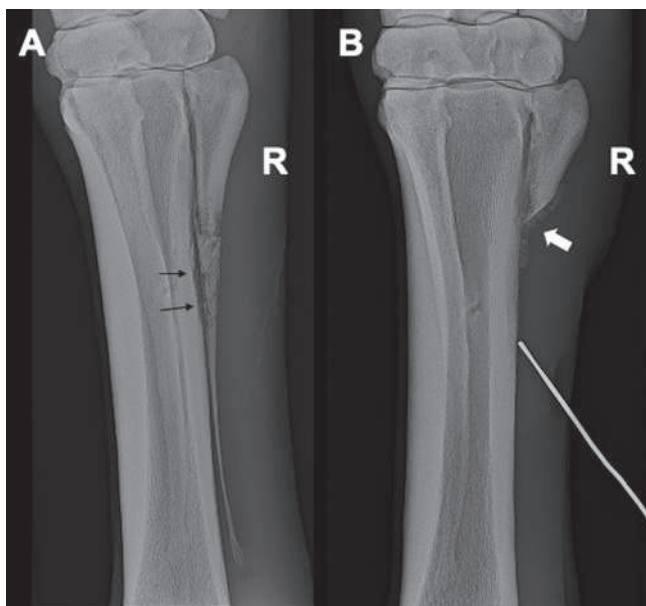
(A) Dorsolateral-palmaromedial oblique radiographic view of the right MCIV in case 5 (10 days after injury). Moderate diffuse soft tissue swelling around MCIV and multiple faint fracture lines in MCIV are evident, and the overall bone opacity of the fractured area of MCIV is markedly reduced. Mild irregular new bone formation with permeative lysis of the cortices of MCIII and MCIV are apparent in the metacarpal interosseus space indicative of osteomyelitis (black arrows). (B) Dorsolateral-palmaromedial oblique radiographic view of the right MCIV in case 5 (6 weeks after surgery): Moderate soft tissue swelling and irregular palisading periosteal reactions along the abaxial contours of MCIII and MCIV are seen. Persistent irregular new bone formation with permeative lysis within the metacarpal interosseus space is indicative of osteomyelitis (white arrow). A metal probe has been inserted into a draining tract and points toward the distal margin of the periosteal reactions on MCIII. | (A) Röntgenologische dorsolaterale-palmaromediale Schrägaufnahme des rechten MCIV des Fall 5 (10 Tage nach der Verletzung): Mittelgradige, diffuse Weichteilschwellung um den MCIV sowie multiple, undeutliche Frakturlinien innerhalb des MCIV sind sichtbar und die gesamte Knochenichte im frakturierten Bereich des MCIV wirkt deutlich reduziert. Leichtgradige, unregelmäßige Knochenzubildungen sowie permeative Lyse im Bereich der zum Spatium metacarpeum interosseum angrenzenden Kortizes des MCIII und MCIV, welche auf eine Osteomyelitis hinweisen (schwarze Pfeile), sind sichtbar. (B) Röntgenologische dorsolaterale-palmaromediale Schrägaufnahme des rechten MCIV des Fall 5 (6 Wochen nach der chirurgischen Therapie): Mittelgradige Weichteilschwellung und unregelmäßige, palissadenartige periostale Reaktionen entlang der abaxialen Konturen des MCIII und MCIV sind sichtbar. Persistierende, unregelmäßige Knochenzubildungen sowie permeative Lyse im Bereich des Spatium metacarpeum interosseum sind hinweisend für Osteomyelitis (weißer Pfeil). Eine Metallsonde wurde in den Fistelkanal eingeführt und zeigt auf den distalen Rand der periostalen Reaktionen des MCIII.
